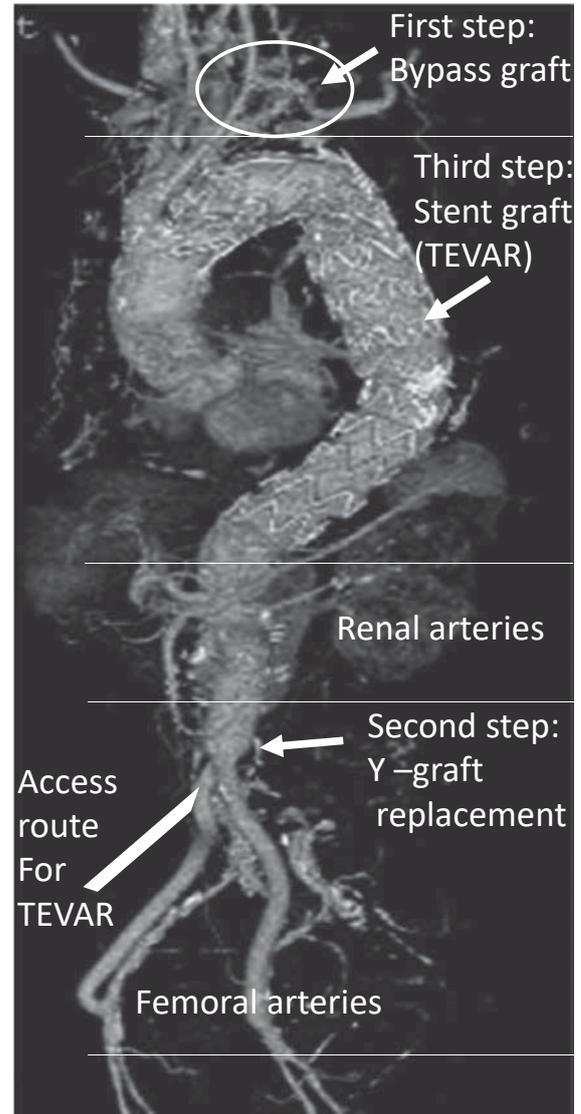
Postoperative CT shows no endo-leak and complete obliteration of the aneurysmal sac. The bypass graft between the left carotid artery and the left subclavian artery is patent (white arrow). The white part showed the access route branching graft for TEVAR, which was taken out after procedure completed.
